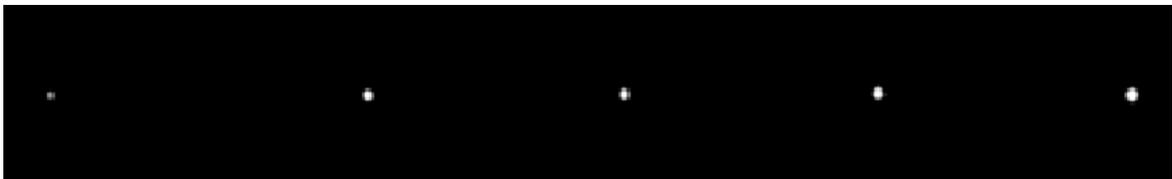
CT slice containing all needle tips, from near-zero penetration (left) to 2.0 mm penetration (right) into slice.
